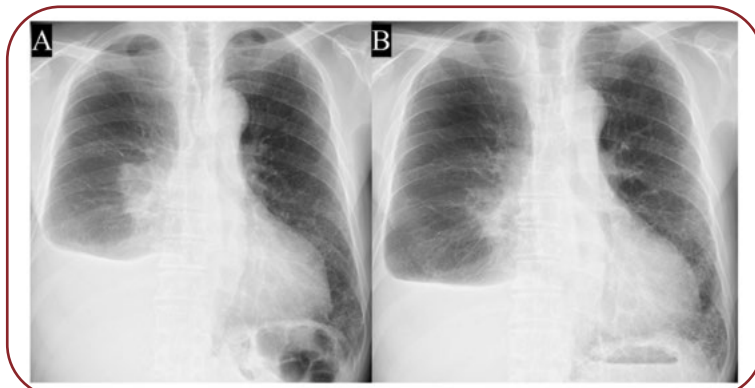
Chest radiographs taken at the initiation of chemotherapy (A) and at the time of two courses after chemotherapy (B) showing shrinkage of the nodule and decrease of the right pleural fluid and a small right-sided pneumothorax
